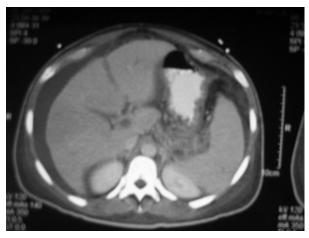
Abdominal CT scan showing acute pancreatitis with peripancreatic fluid collections.
